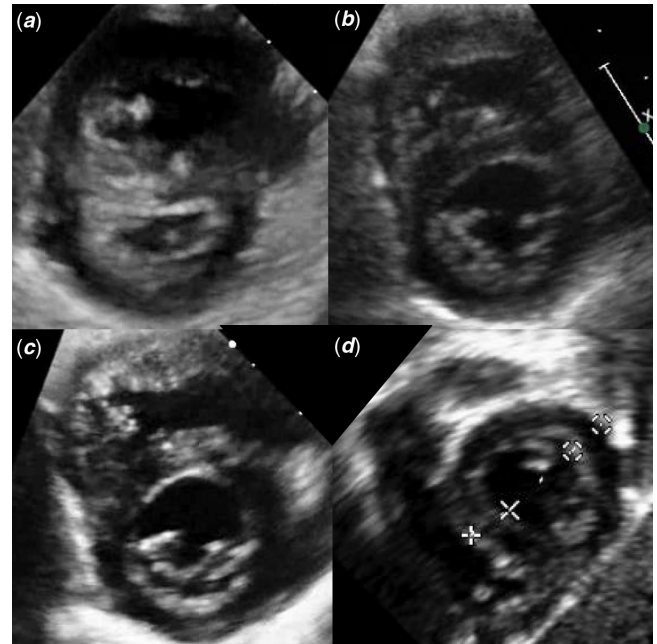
Parasternal short-axis end-systolic echocardiogram images over the course of therapy. (a) Severe septal flattening before administration of treprostinil. (b) Trivial septal flattening while receiving treprostinil 50 ng/kg/minute. (c) No septal flattening after transition to enteral selexipag. (d) Mild septal flattening 11 months after transition to enteral selexipag.
